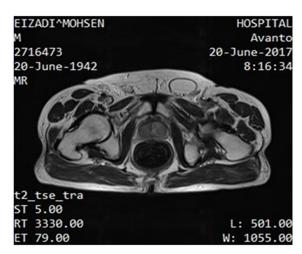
Recent T-2weighted MRI
